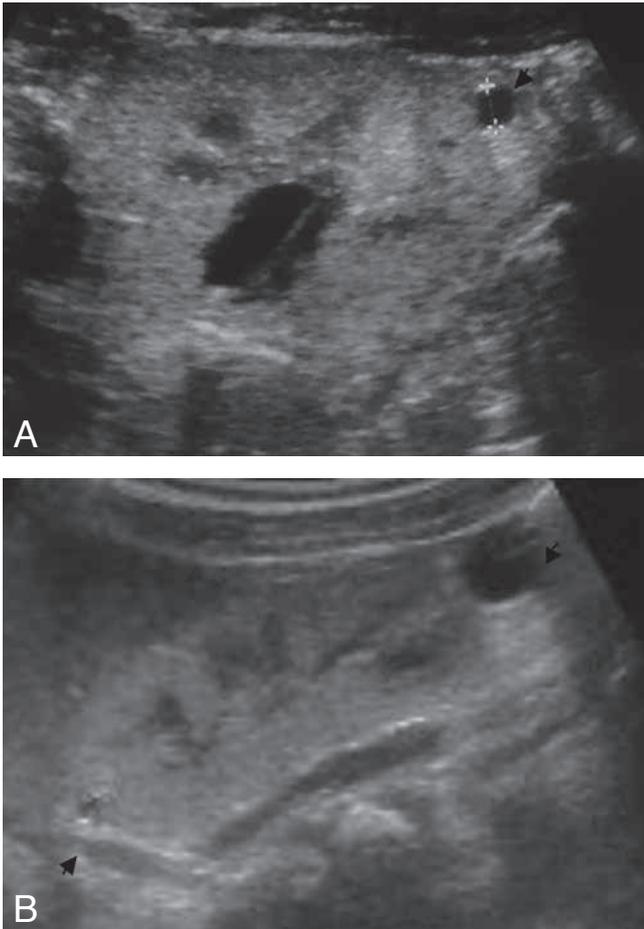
7-day-old. Transverse (A) and coronal (B) ultrasound scan show right kidney with cysts (arrows) in the peripheral cortex.
